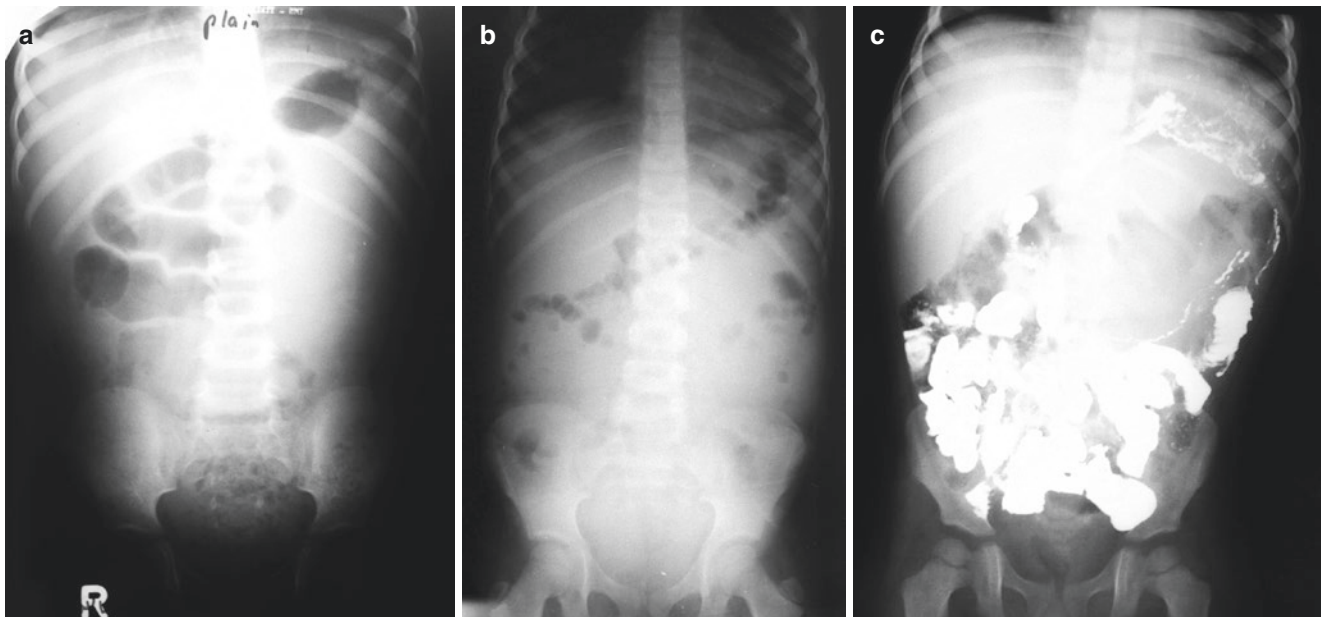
(a) Plain X-ray showing a tumour mass in the abdomen. Burkitt's lymphoma. (b) Plain X-ray of Burkitt's lymphoma showing little gas in the bowel due to compression of the lymphoma. (c) Barium meal and follow through in Burkitt's lymphoma
